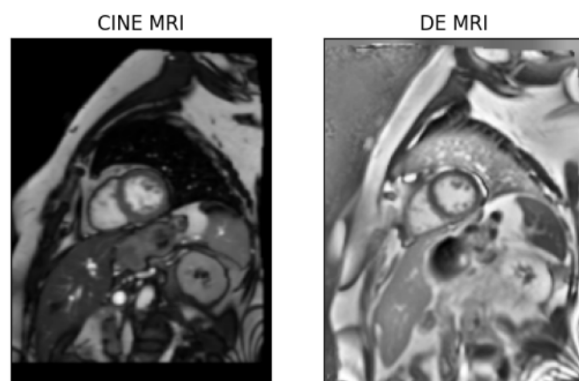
Cine and DE MRI slices in short-axis orientation corresponding to the same patient and localization.
